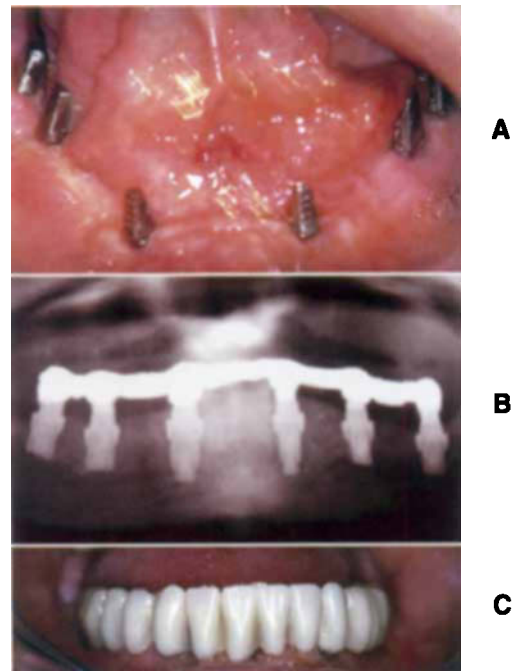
■ One-stage combination root form and plate/blade form implants supporting a complete arch fixed restoration. Healed implants (A), radiograph of splinted coping/retention bar mesostructure cemented in position (B), and seated acrylic semi-fixed flangeless overdenture (C).
